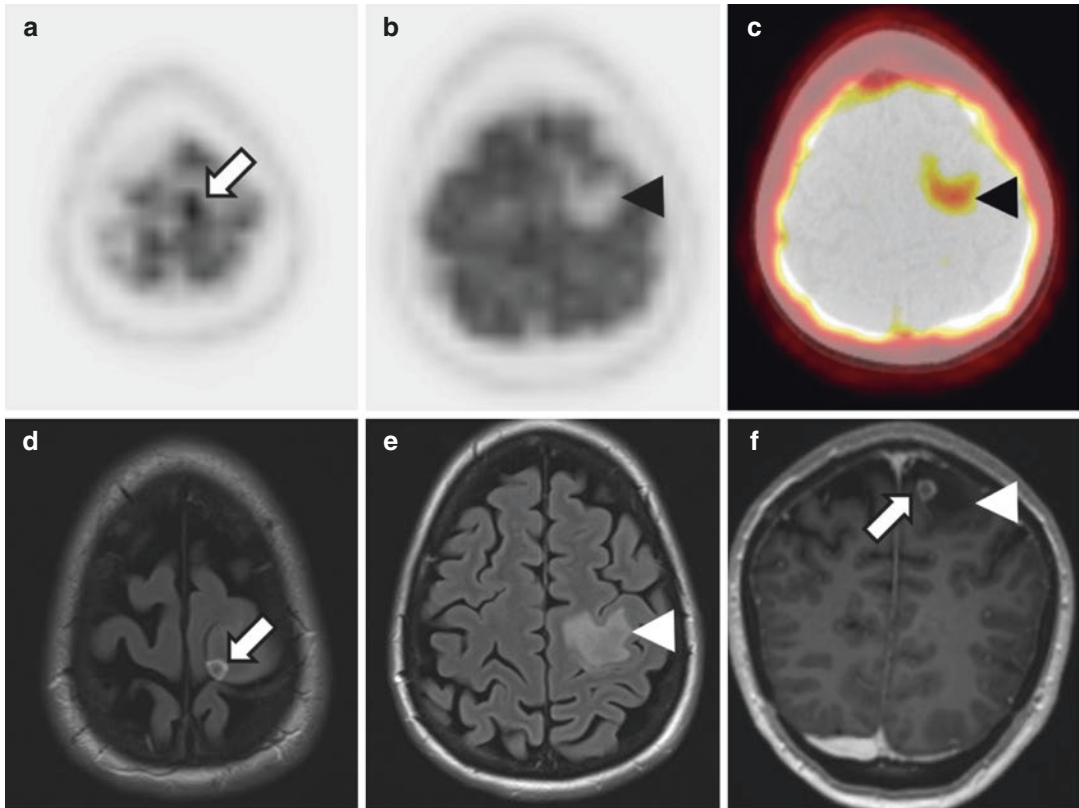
Brain metastasis detected in a 43-year-old woman with NSCLC (not otherwise specified) stage UICC IV. (a, b) FDG-PET; (c) hybrid PET/CT image; (d, e) T2-weighted fluid-attenuated inversion recovery (FLAIR), (f) T1w gradient-echo post-Gd. The presence of this small brain metastasis in the cortex of the left pre-central gyrus (*arrows*) becomes mainly evident through
